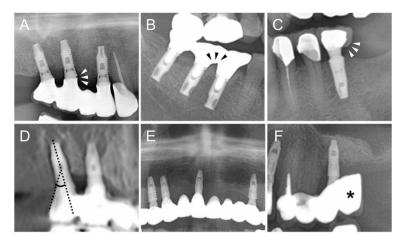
Radiographic evaluation of prosthetic factors associated with MRONJ. (A) Implant prosthesis margin (arrowheads, misfit), (B) embrasure space (arrowheads, no space), (C) emergence profile (arrowheads, convex), (D) emergence angle (dotted lines, reference lines for measurements), (E) span of prosthesis, (F) cantilever extension (asterisk, distal extension).
